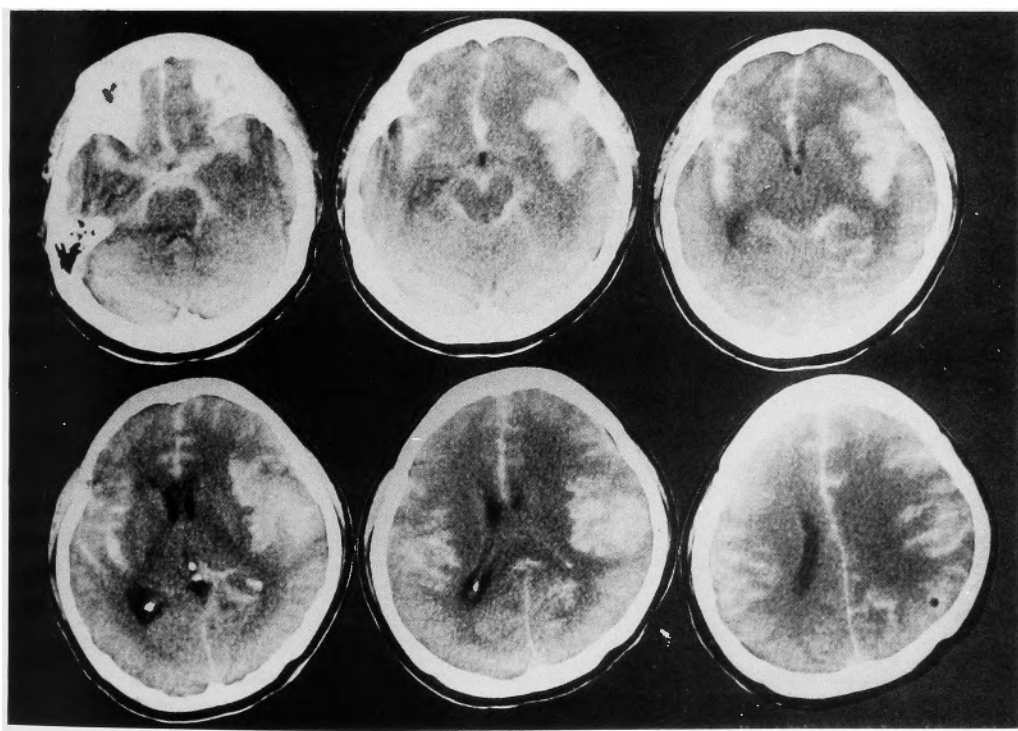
CT scan showing massive subarachnoid hemorrhage and hematoma in the right Sylvian fissure.
